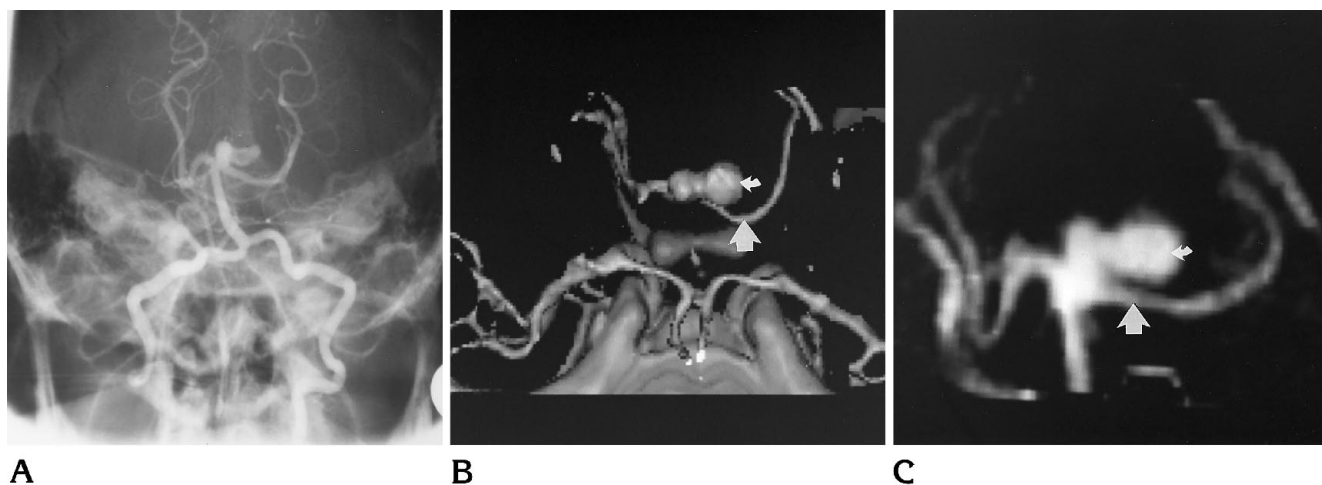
A, Steep Townes projection from vertebral angiogram shows basilar tip aneurysm with loculus directed to the left. B and C, Surface-rendered 3-D CTA viewed from directly above (B) and maximum-intensity projection 3-D CTA viewed from anteriorly (C) show the relationship of the loculus (small arrow) of the aneurysm to the left P1 segment (large arrow).
